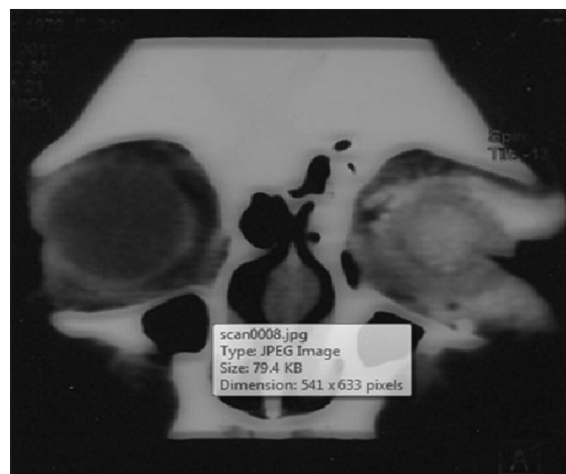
Orbital computed tomography scan shows hyperdense homogenous round opacity corresponding to silicone oil in the anterior half of the left vitreous cavity and lateral aspect of the left orbit
